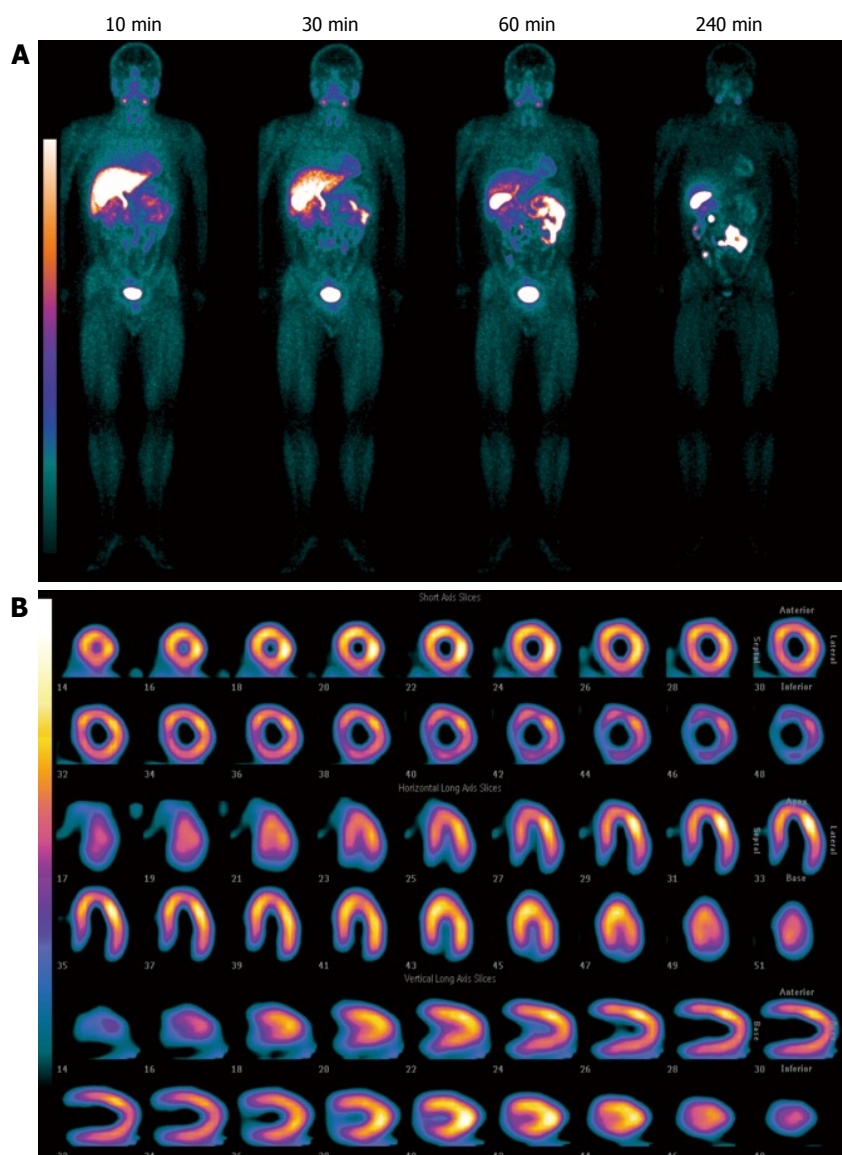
The whole-body images of representative a healthy volunteer administered with $^{99m}\text{TcN-MPO}$. A: Administered with $^{99m}\text{TcN-MPO}$ (~25 mCi) at 10, 30, 60 and 240 min post-injection; B: Representative SPECT images of the heart after administration of $^{99m}\text{TcN-MPO}$ (~25 mCi) at 60 min post-injection.
